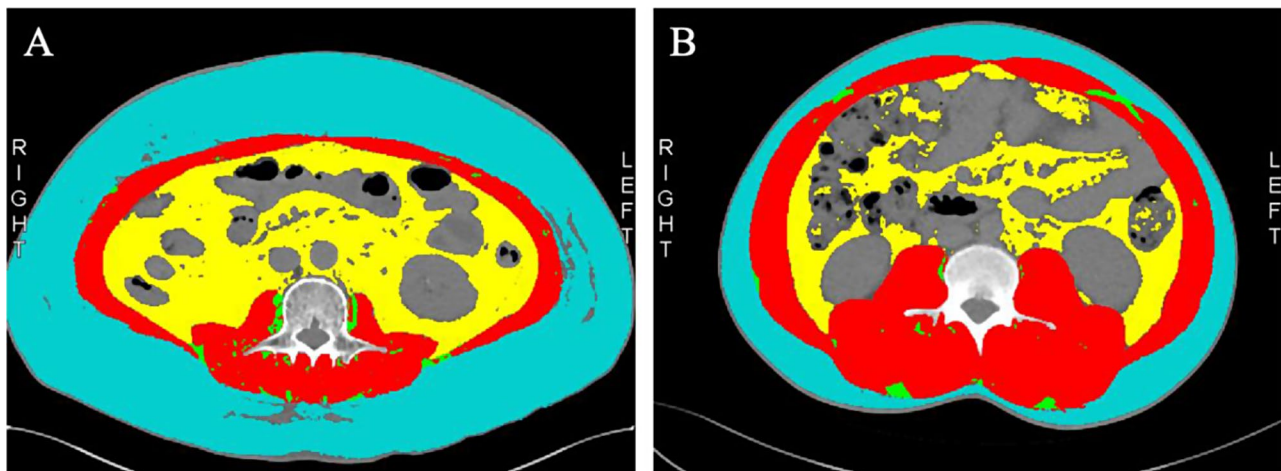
Cross-section of CT-scan images at the L3 region from two typical recipients with or without sarcopenia. (A) sarcopenia; (B) non-sarcopenia. Red: skeletal muscle; Blue: subcutaneous adipose tissue; Yellow: visceral adipose tissue; Green: intermuscular adipose tissue
